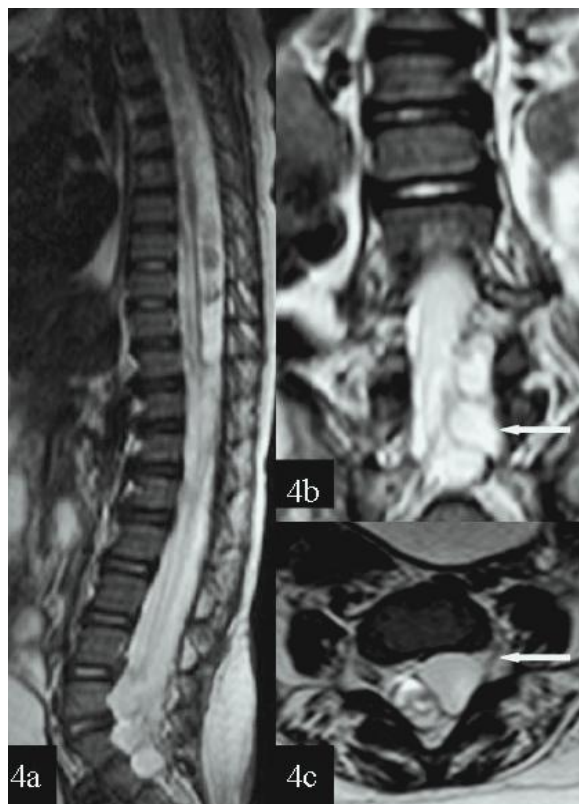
a-c: Sagittal, coronal, and axial T2-weighted spin-echo MRI. 4a. Thoracolumbar myelopathy, 4b-c. Nerve root avulsion and intraspinal pseudomeningocele on the left lumbosacral nerve root.
